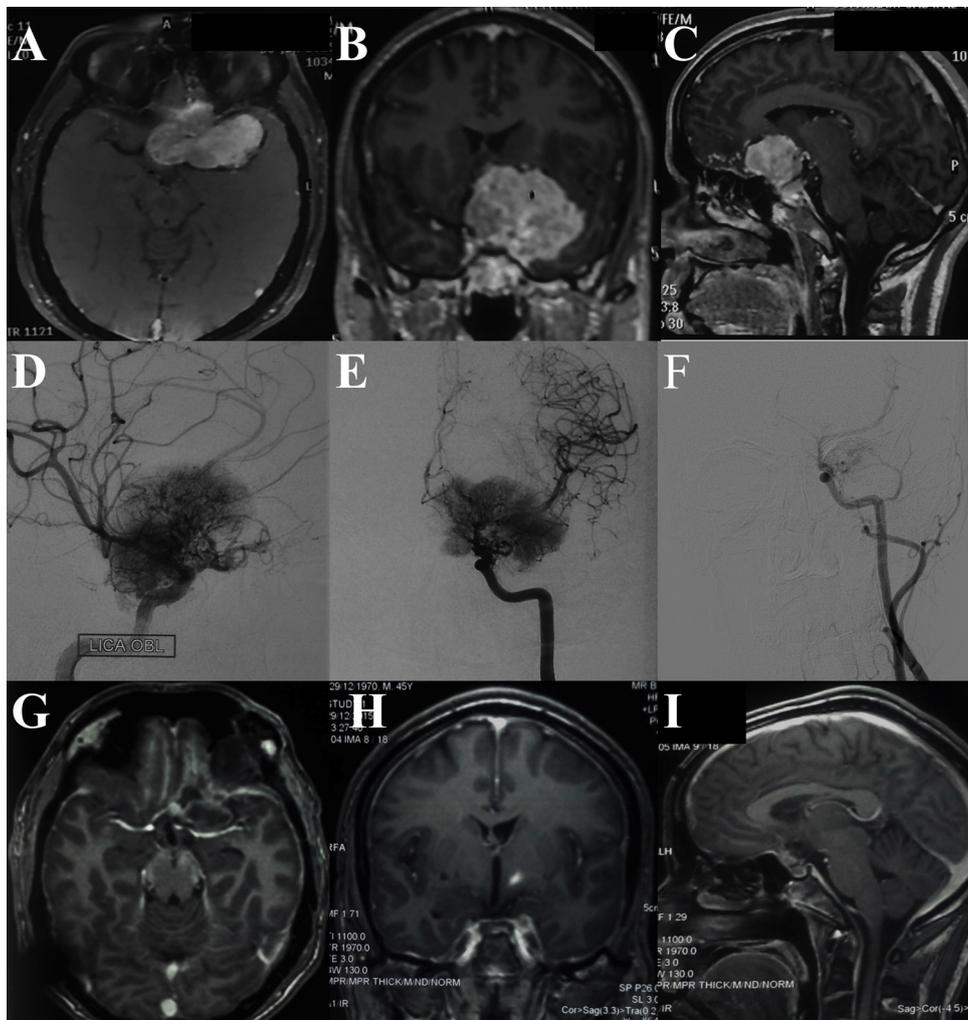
A–C) Preoperative Contrast MRI in axial, coronal and sagittal plane showing clinoid meningioma with encasement of arteries. D&E) DSA (lateral & oblique) showing intense blush from ipsilateral ICA with irregular narrowing of ICA, A1 and M1 F) DSA with injection from ECA showing no blush G)–I) Follow up MRI at 3 months postoperative period showing good resection.
